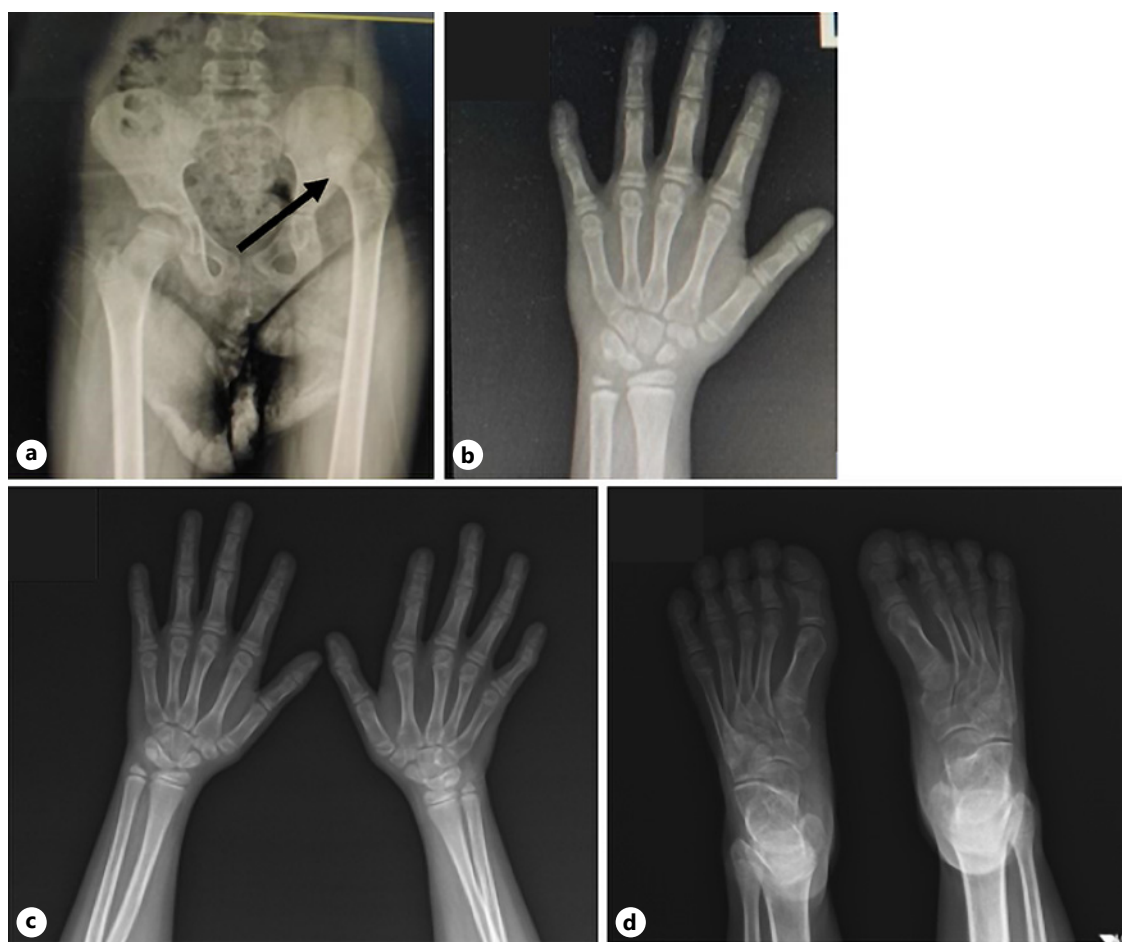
Bone radiographic imaging. a The patient had an advanced stage developmental dysplasia of the hip with a very shallow left acetabulum and significant degeneration in the femoral head (indicated with an arrow). b, c Brachydactyly, brachymesophalangia, and clinodactyly in the fifth finger are observed in the radiograph of the hands. d Clinodactyly is observed in both toes.
